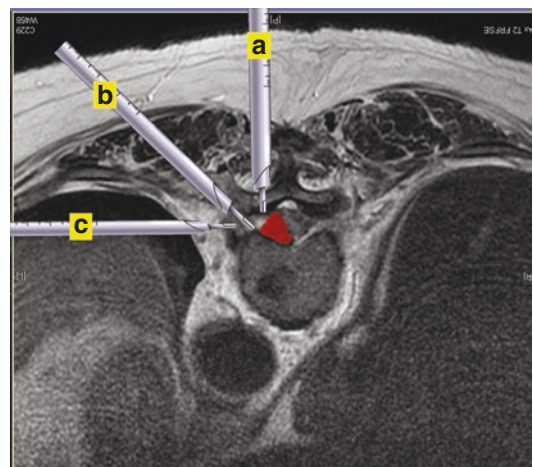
Different trajectories of full-endoscopic approach for paramedian TDH. (a) Interlaminar; (b) Transforaminal; (c) Transthoracic retropleural
